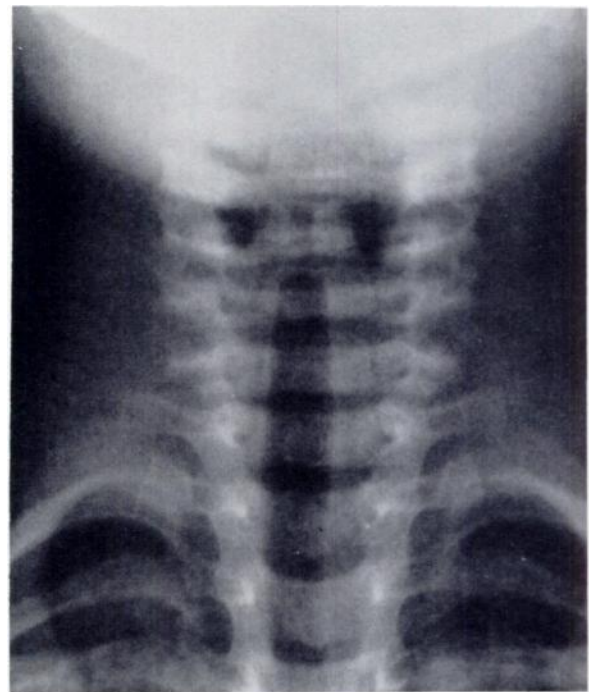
Normal anteroposterior airway radiograph in 19-month-old child showing true vocal cords at level of inferior extent of air-filled pyriform sinuses. Subglottic airway has shouldered appearance, with superolateral convexity of upper margins.
